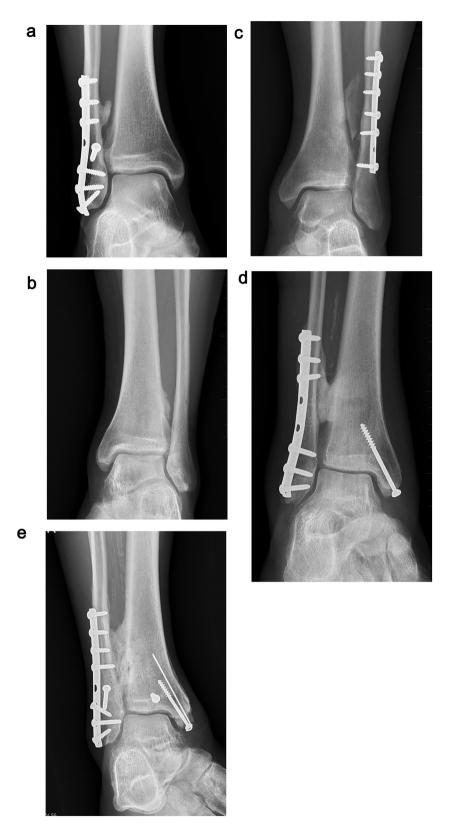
X-ray images of incomplete bony bridging and complete synostosis: (a) fibular, (b) tibial – X-ray after metal extraction, (c) isolated bone formation in the interosseous membrane, (d) complete tibiofibular synostosis above syndesmosis, (e) complete tibiofibular synostosis in the area of the syndesmosis.
